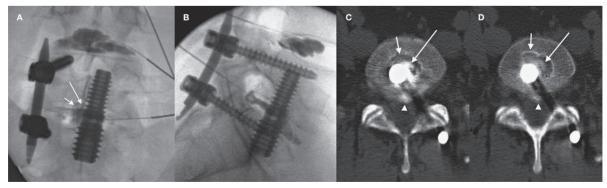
Patient is a 33-year-old man with a longstanding history of chronic low back pain after a lifting injury. Three months earlier the patient had had left-sided pedicle fixation and trans-sacral screw placement at L5-S1. Post-fusion, he continued to have 9/10 low back pain. At diskography, the patient had 9-10/10 positive concordant pain at L5-S1 with partial improvement of provoked pain with lidocaine injection. A,B) Frontal and lateral diskographic images demonstrate contrast seen pooling around the trans-sacral screw (large arrow) with active leakage (small arrow). C,D) Post diskogram CT demonstrates contrast surrounding the trans-sacral screw (large arrow) and peri-trans-sacral screw fibrous tissue (small arrow) with contrast leakage into the anterior epidural space (arrowhead). Subsequently, he was surgically revised with significant improvement.
